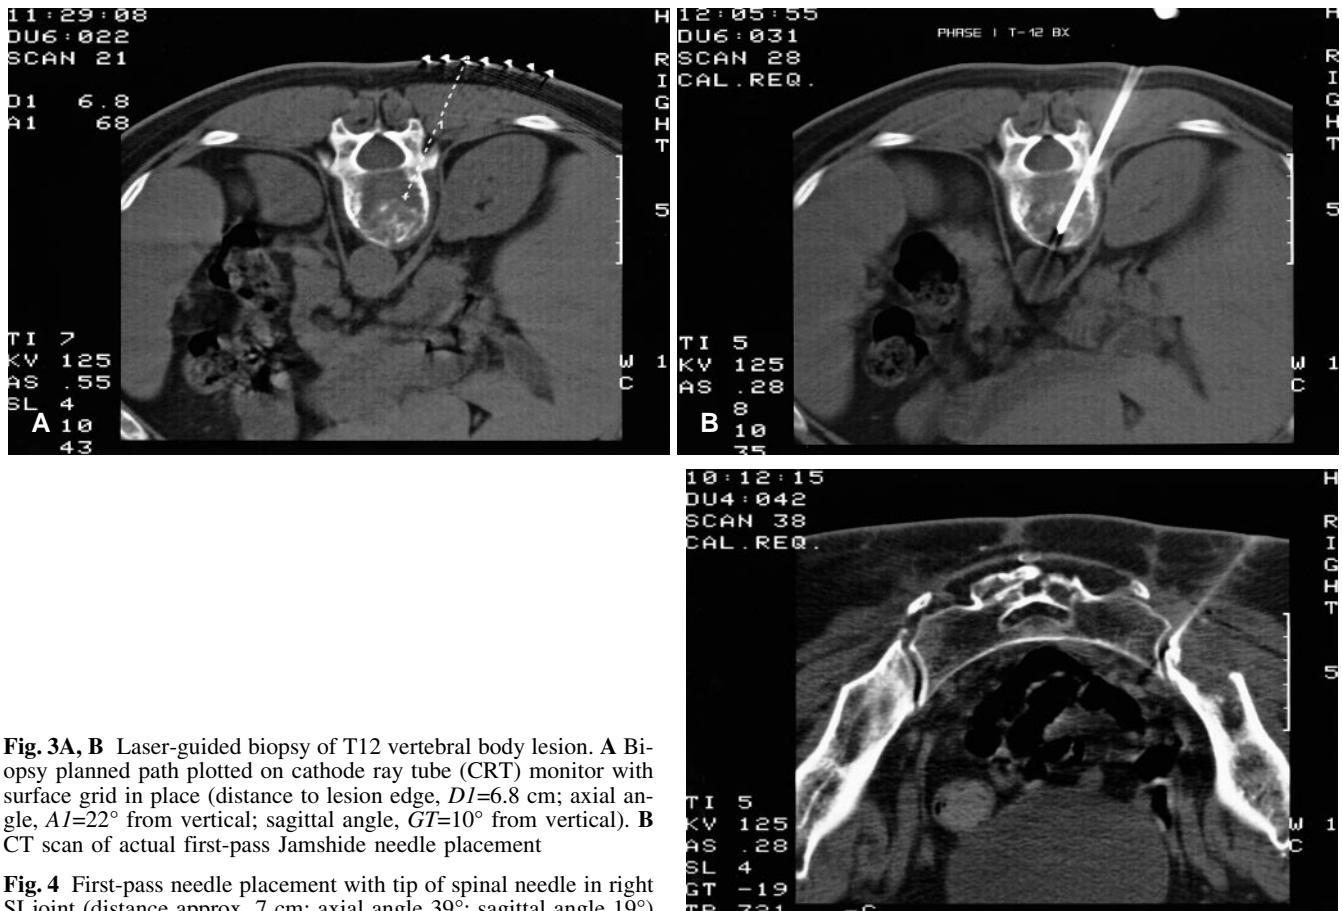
Laser-guided biopsy of T12 vertebral body lesion. A Biopsy planned path plotted on cathode ray tube (CRT) monitor with surface grid in place (distance to lesion edge, $D1=6.8$ cm; axial angle, $A1=22^\circ$ from vertical; sagittal angle, $GT=10^\circ$ from vertical). B CT scan of actual first-pass Jamshide needle placement
